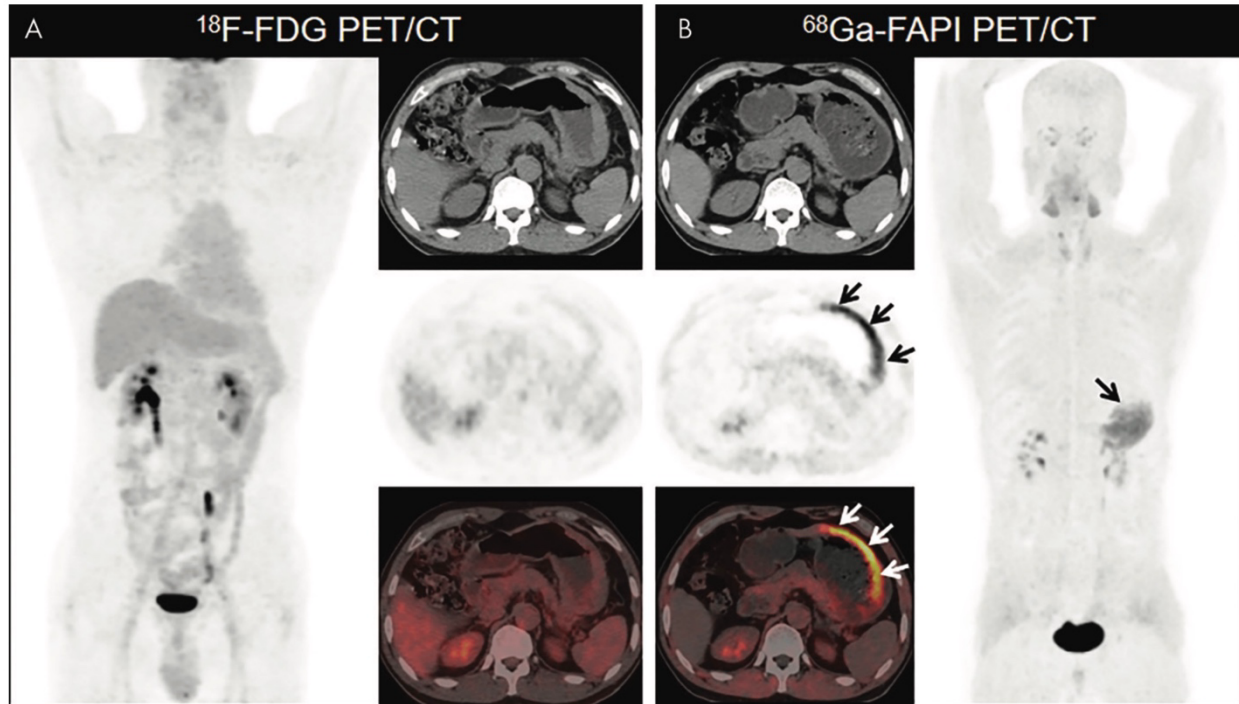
Images from a 55-year-old man with known gastric signet ring cell carcinoma who underwent [^{18}F]FDG PET/CT for initial staging. *A*, Images from [^{18}F]FDG PET/CT demonstrating normal findings (left image: anterior maximum intensity projection image obtained using [^{18}F]FDG PET; right upper image: axial unenhanced CT image; right middle image: axial PET image; right lower image: axial fused PET/CT image). *B*, Images obtained during [^{68}Ga]FAPI PET/CT performed for further evaluation revealed intense [^{68}Ga]FAPI uptake along the gastric wall (arrows) (maximum standardized uptake value, 11) (right image: anterior maximum intensity projection image obtained using [^{18}F]FDG PET; left upper image: axial unenhanced CT image; left middle image: axial PET image; left lower image: axial fused PET/CT image). No distant metastasis was observed.
